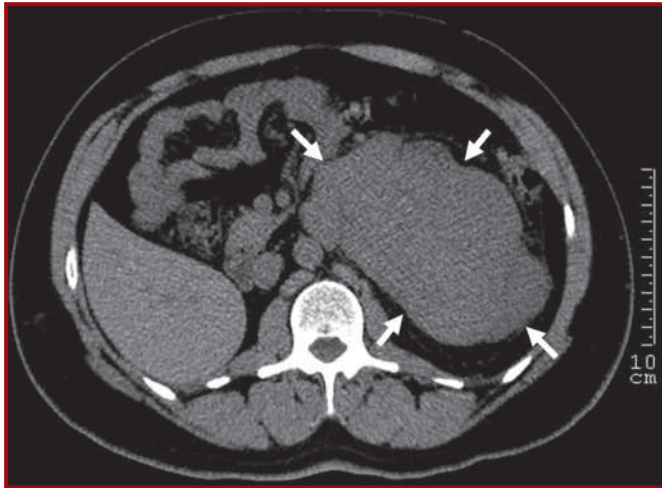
Abdominal axial non-contrast computed tomography scan revealed a large hypodense solid mass (white arrows)
